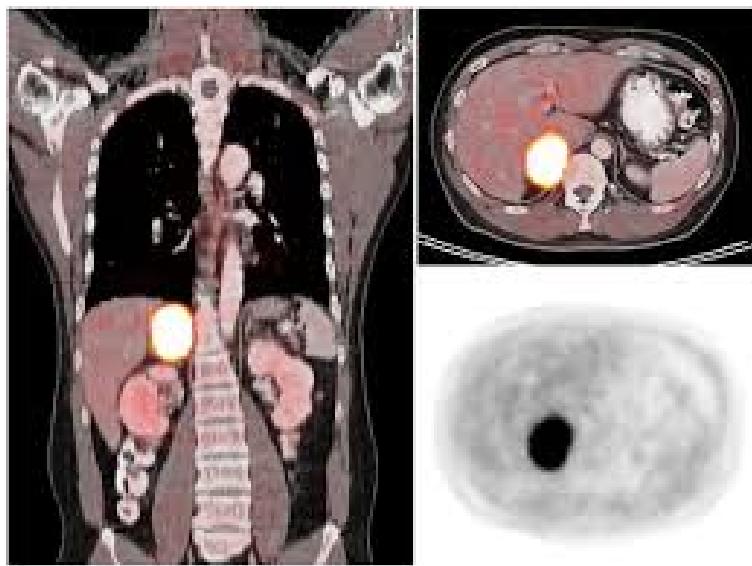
F-18 Flurodopamine PET-CT shows a right pheochromocytoma.
